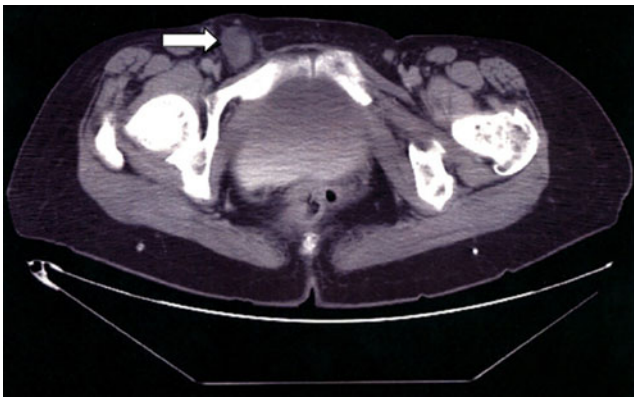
Representative axial slice of CT scan. Inflamed appendix is noted within inguinal canal (*white arrow*)
